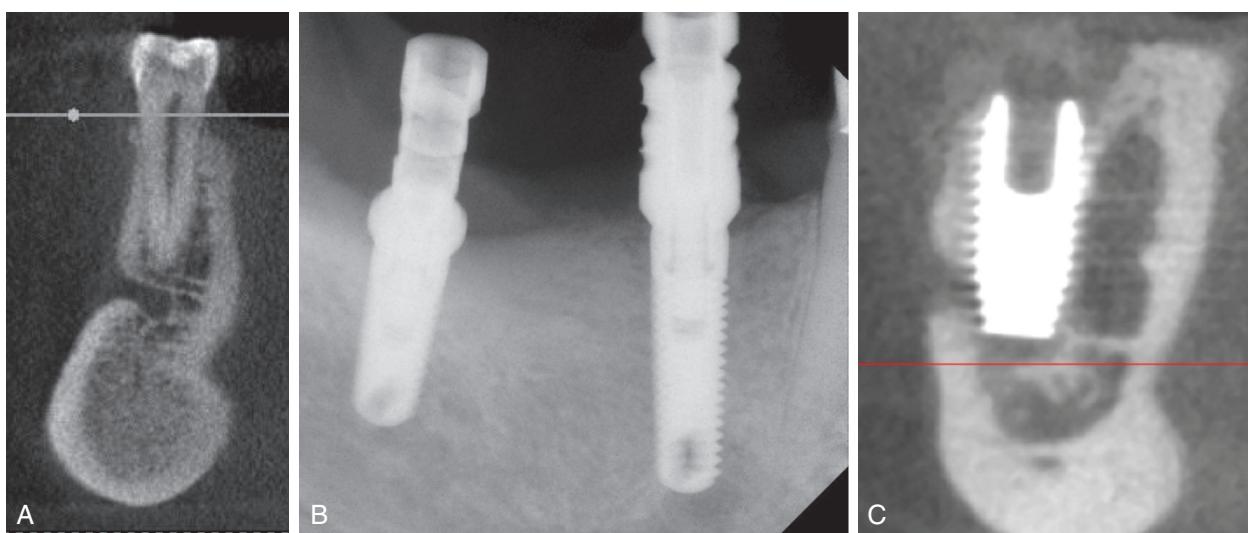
(A) CBCT revealing close proximity of root apex to mental foramen. The root apex is inferior to the mental foramen. (B) Complications arising from simultaneous extraction and implant placement in premolar area. (C) Implant placed into mental foramen location.
